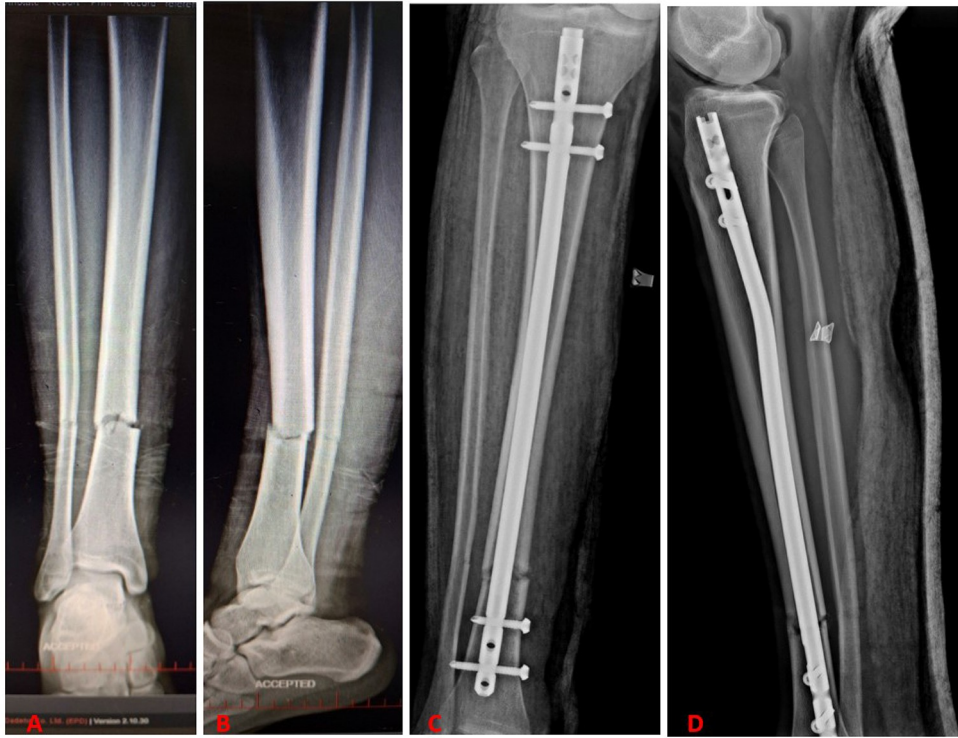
Radiographs of a 56-year-old man with tibia shaft fracture (A, B) managed by static intramedullary nailing at 16 weeks (B, D), united at 22 weeks.
